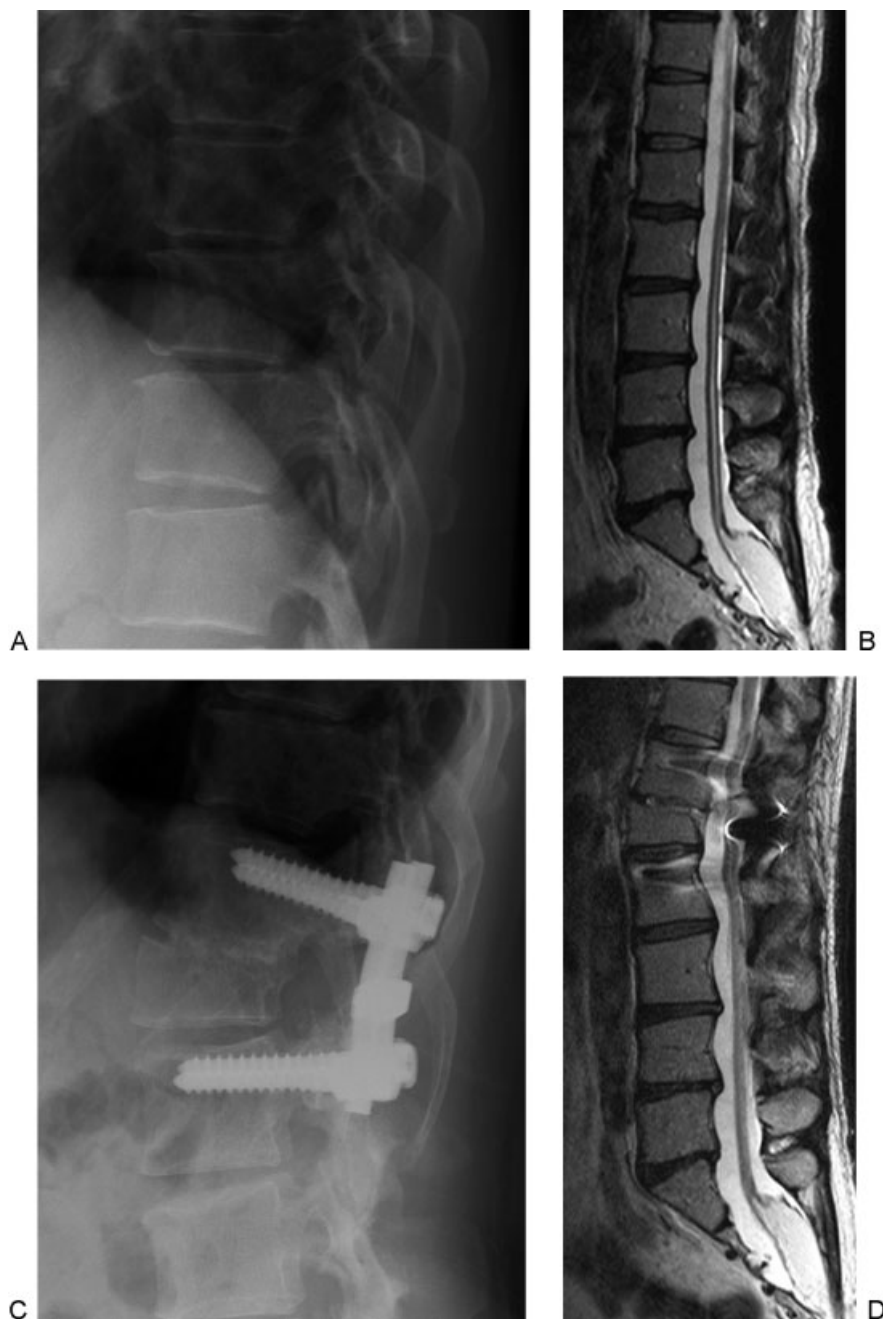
A representative case of spine-shortening osteotomy. (A) Preoperative lateral radiograph. (B) Preoperative sagittal T2-weighted magnetic resonance imaging (MRI) scan shows a low-placed conus medullaris and terminal filum connected with a subcutaneous lipomyelomeningocele at the S1–S2 level. (C) Postoperative lateral radiograph 3 years after surgery shows complete bone union and significant spine shortening. (D) Postoperative sagittal T2-weighted MRI scan obtained 1 year after surgery. The spinal cord tension was relieved after surgery as shown by preoperative MRI.
